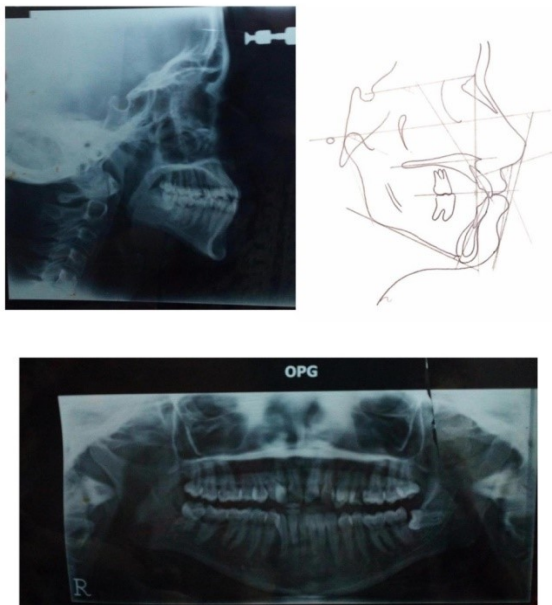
Pretreatment cephalometric radiograph and its tracing and orthopantomogram
